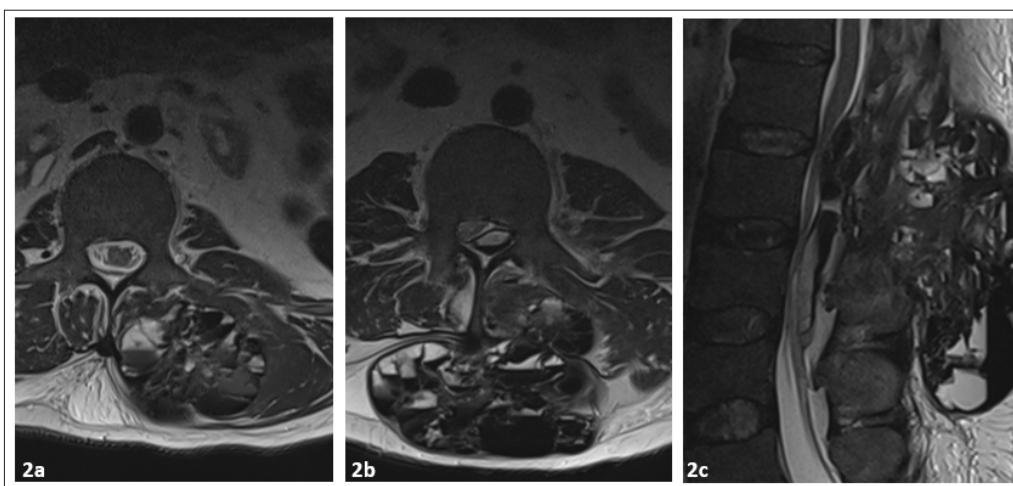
Lumbar axial (2a) T2W MRI Showing L1 Periarticular Lesions with Fluid-Filled Levels, Axial (2b) Image Showing Spinal Canal Stenosis at the Level of L3. Sagittal (2c) Lumbar T2W MRI Demonstrating Severe Spinal Canal Stenosis from L1 to L3 Level.
